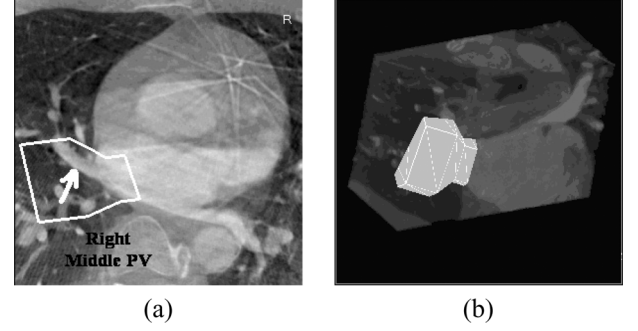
Region of interest (ROI) for the right middle pulmonary vein extraction. (a) ROI overlaid on trans-axial slice of a C-arm CT volume. (b) ROI mesh embedded in a 3-D visualization of the data.
